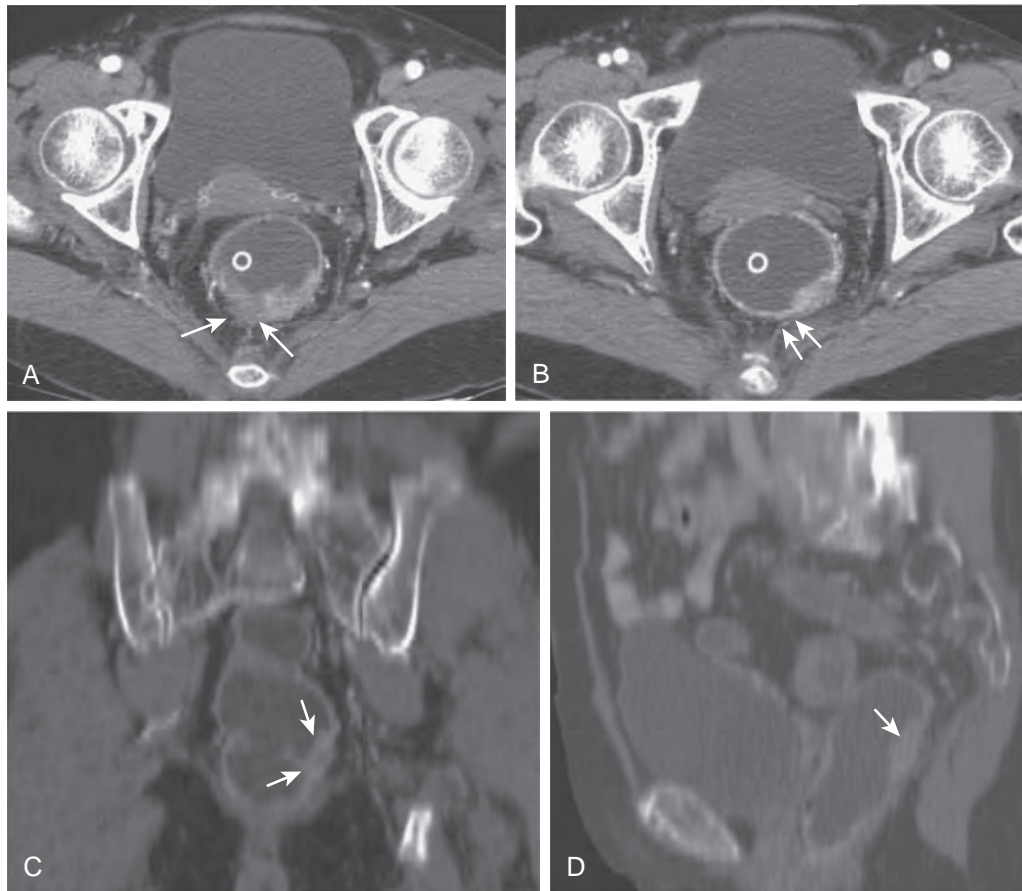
CT scan of rectal tumor with extension beyond the wall (T3N0M0; Dukes' stage B2). A. The thin-section MDCT scan in the arterial phase reveals nodular broad-based extensions of soft tissue density (arrows) into the perirectal fat indicative of tumor invasion. B. MDCT scan slightly below the level in A shows a focal mass with some spiculation (arrows). This feature is more suggestive of desmoplastic reaction without tumor cells rather than infiltration of tumor into perirectal fat. This distinction is not always possible on MDCT. C. The coronal MPR reveals the nodular outer surface of the tumor (arrows). D. The sagittal MPR does not demonstrate this feature effectively. The mass is located in posterior wall (arrow) of upper rectum.
